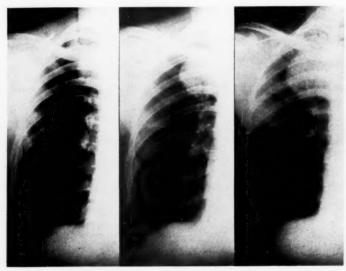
At the time of the left-hand roentgenogram (4-5-40) the patient, a male, age 47, was admitted to a well-known tuberculosis sanatorium because of fatigue and bloody, mucoid sputum, of one month's duration, but without pain, anemia or loss of weight. Tuberculosis was tentatively diagnosed. During the following four months, nine examinations of the sputum were negative for tubercle bacilli. A malignant neoplasm was promptly suspected, but operation was deferred because of two negative bronchoscopic examinations, and in spite of the progressive growth of the lesion as seen in the subsequent roentgenograms of 7-9-40 (middle) and 9-1-40 (right).
